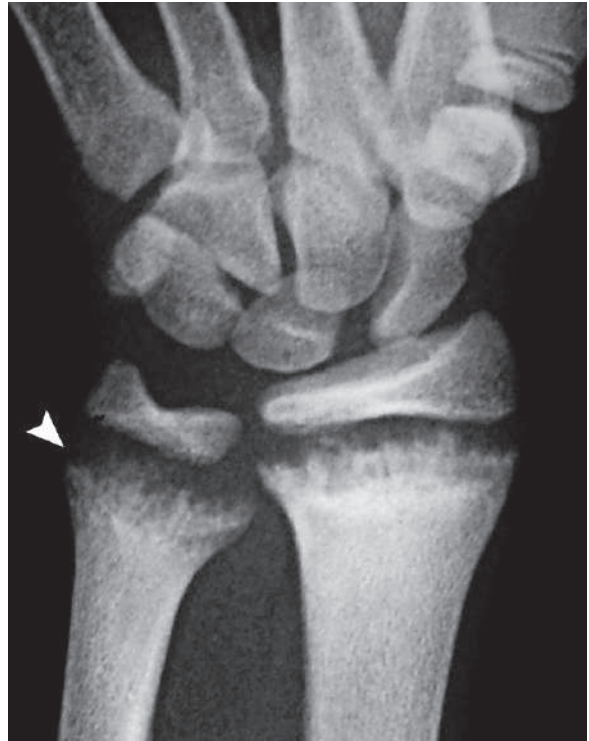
A plain wrist radiograph of a patient with rickets shows metaphyseal bony speculations (*arrowhead*)
